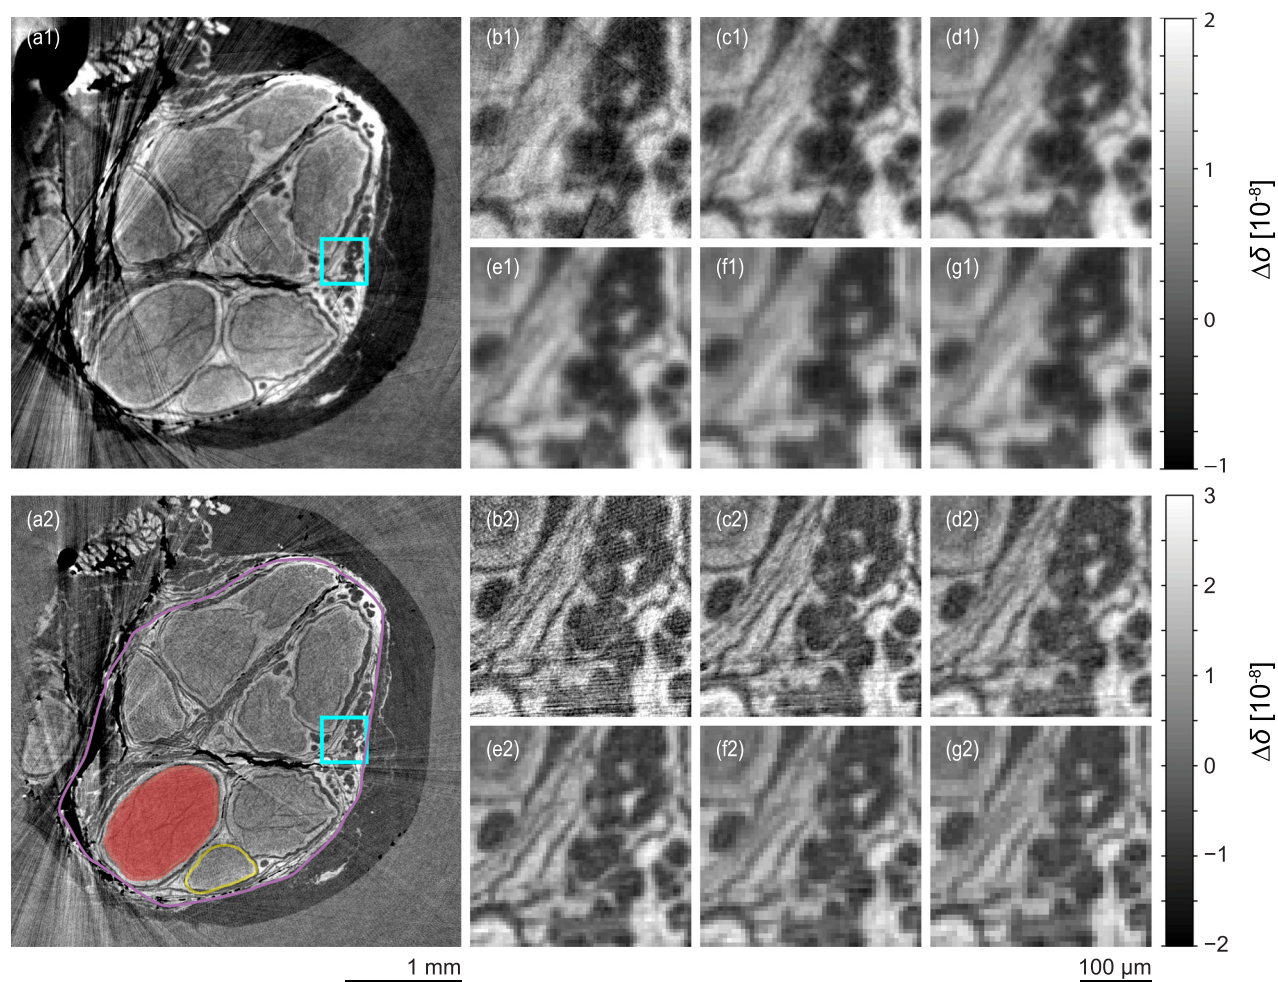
X-ray phase tomography slice (a) of the human nerve using XDGI (top) and XSGI (bottom). The epineurium (violet), perineurium (yellow), and endoneurium (red) are clearly distinguishable for both techniques. The region enclosed by the cyan square is displayed for binning factors of  $1 \times 1$  (b),  $2 \times 2$  (c),  $3 \times 3$  (d),  $4 \times 4$  (e),  $5 \times 5$  (f), and  $6 \times 6$  (g). For both techniques, the grayscale bar was optimized for the respective figure displayed in (c), see also Fig. 2.
